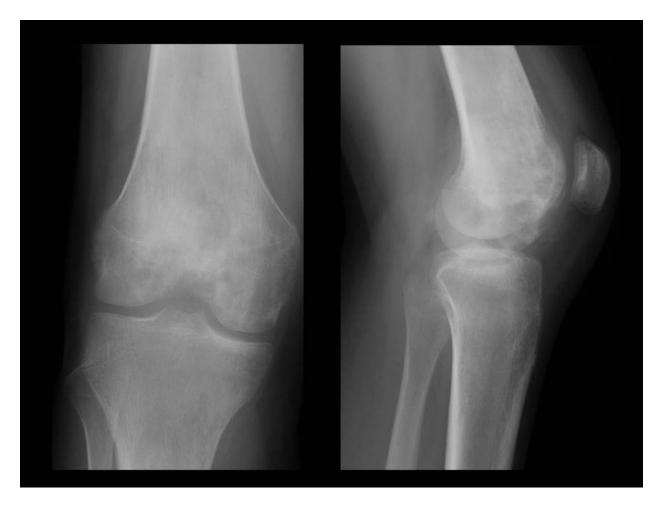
Type II Moth-eaten lesion. Radiography shows multiple small destructive foci of a bone lesion with ill-defined margins and wide zone of transition - Osteossarcoma.
